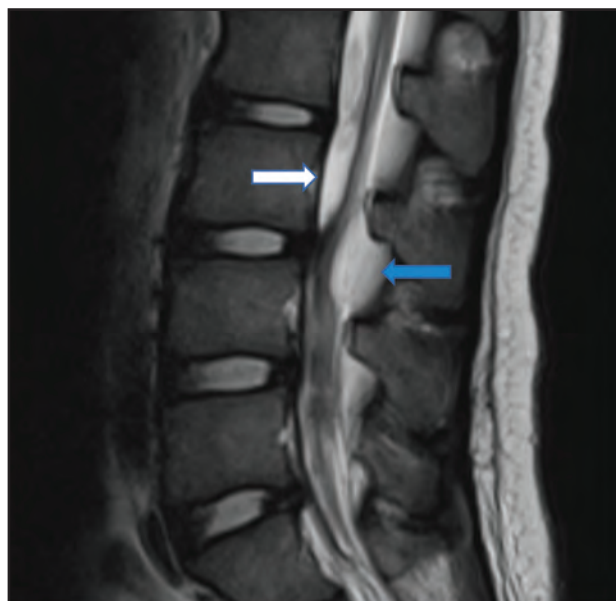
Lumbar MRI – sagittal section. T2-weighted sagittal image showing another cyst seen posteriorly and slightly inferiorly at L3/L4 level (blue arrow). These cysts caused mass effect to adjacent nerve roots.
